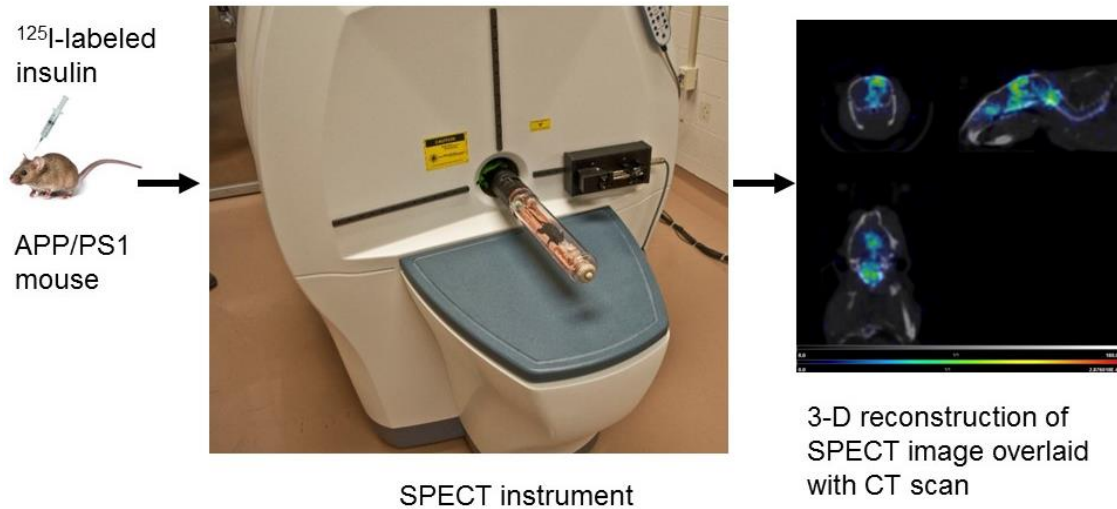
Pictorial representation of an in-vivo experiment involving SPECT/CT imaging.
